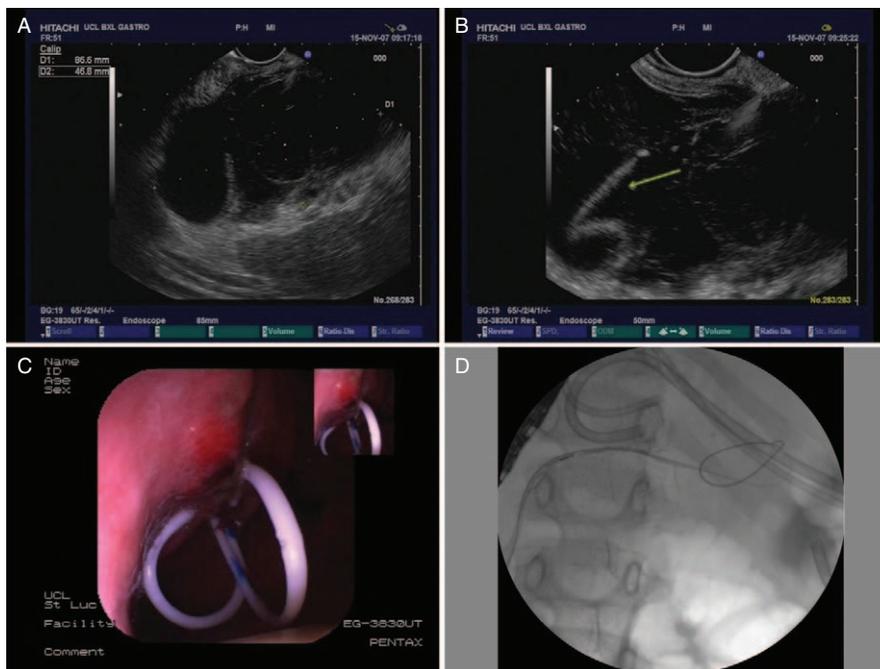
EUS-guided pancreatic pseudocyst drainage (patient number 22). (A) EUS imaging of the pseudocyst (arrow). (B) A 0.035-in. Jagwire inserted inside the cyst (arrow). (C) An endoscopic view of the 7F and 10F cystogastrostomy double pigtail plastic stents. (D) A fluoroscopic image of 2 cystogastrostomy plastic stents, with disruption of the pancreatic tail. The guidewire inserted into the MPD arrives via the fistula into the pseudocyst and coils inside the fluid collection. EUS = endoscopic ultrasonography; MPD = main pancreatic duct.
